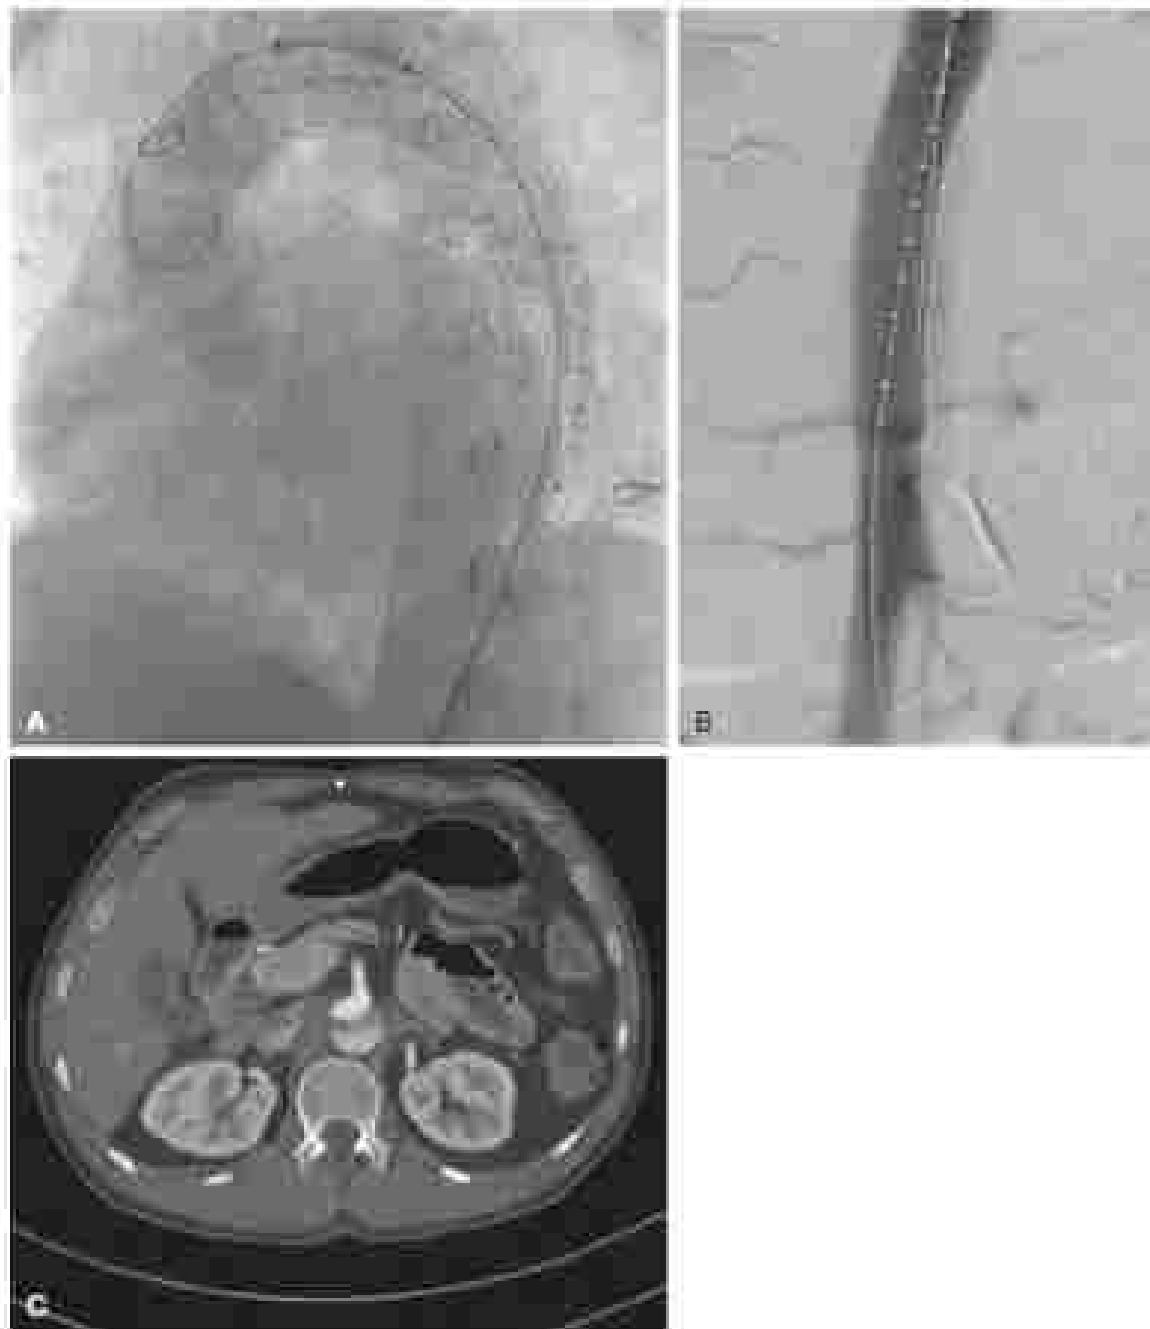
Operative and postoperative imaging for patient shown in Figure 1. (A) Disposition of thoracic aortic graft, overlapping site of preoperative total aorta. (B) Completion angiogram demonstrating antero-lateral, renal, and visceral artery perfusion. Faint calcification of the thoracic false lumen is filling retrograde and likely resulting from a thrombus in the superior to the stented segment of the aorta. (C) 14-month follow-up computed tomography scan demonstrating preferential filling of anterior true lumen, with continued visceral perfusion via patent superior mesenteric artery. The false lumen is apparent and is less dense than contrast density, consistent with progressive thrombosis.
